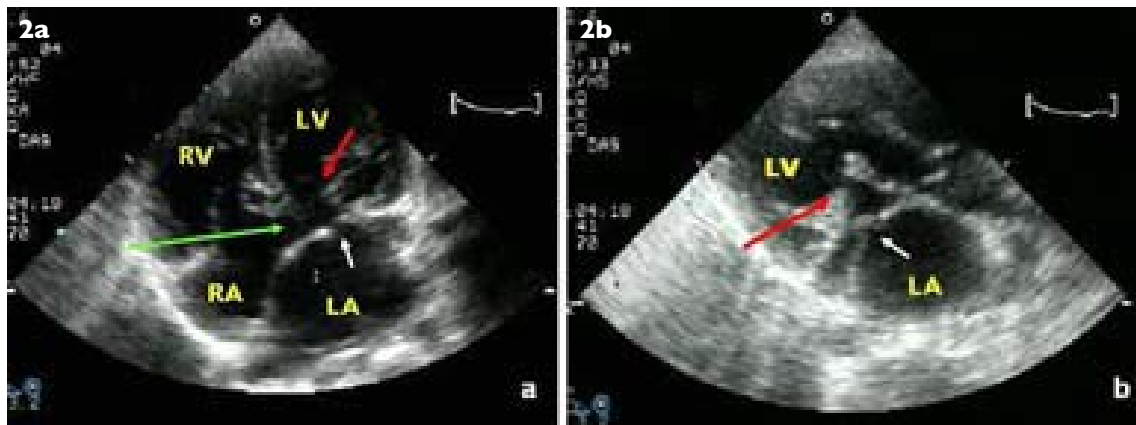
Transthoracic echocardiographical (a) apical four chamber and (b) parasternal long axis images show a membrane in the left atrium (LA) with central fenestration (white arrow) and ostium-primum defect (green arrow). The mitral valve is opening normally (red arrow).
